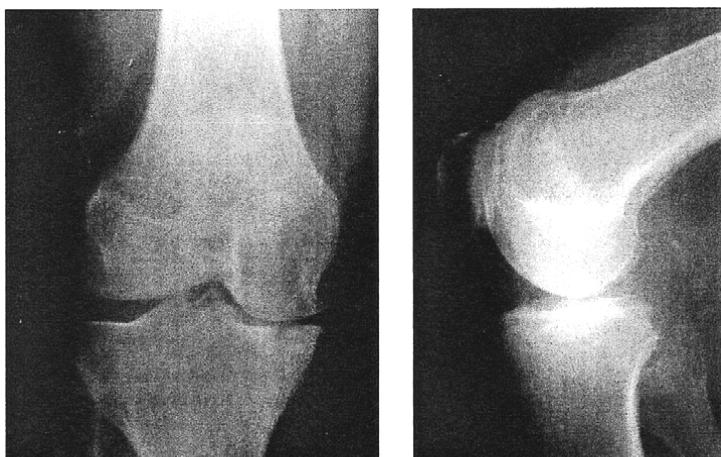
Plain anteroposterior and lateral radiographs showing focal osteonecrosis of the medial tibial plateau.
